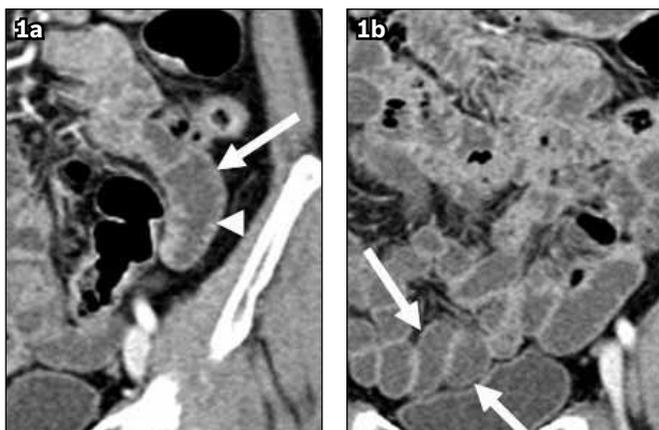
Abdominal CT images of a 56-year-old woman who received 3.8% milk as an oral contrast agent. (a) Grade 3 bowel distension (white arrow), and good mural and mucosal fold visualisations (white arrowhead) are seen for the jejunum. (b) Good discrimination of the bowel loops (white arrows) is seen for the ileum.
